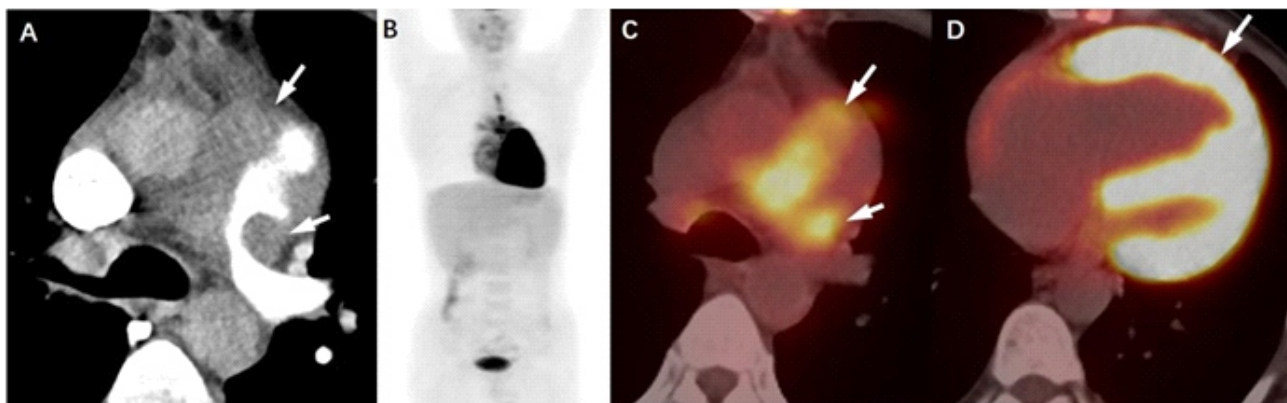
A 46-year-old man presented with a 6-month history of exertional dyspnea. Computed tomography pulmonary angiography (CTPA) manifested multiple filling defects in the main pulmonary artery (MPA), the MPA wall was markedly thickened and the lumen was narrowed (A). The patient underwent a routine whole body ¹⁸F-FDG PET/CT to further evaluate and stage the MPA lesions. While the MPA lesions revealed nodular enhanced glucose metabolism on ¹⁸F-FDG PET/CT, with maximum standardized uptake value (SUVmax) 5.21. Furthermore, the right cardiac enlargement and the right ventricle with a fierce ¹⁸F-FDG activity mimicking the left ventricle were observed, which indicated pulmonary hypertension and right heart dysfunction (B-D). Based on the CTPA and PET findings, neoplastic disease rather than pulmonary embolism (PE) was suspected, such as lymphoma or sarcoma. The diagnosis of low-grade of lymphomatoid granulomatosis (LYG) involving MPA was made after the transcatheter MPA biopsies and multi-disciplinary consultation.
